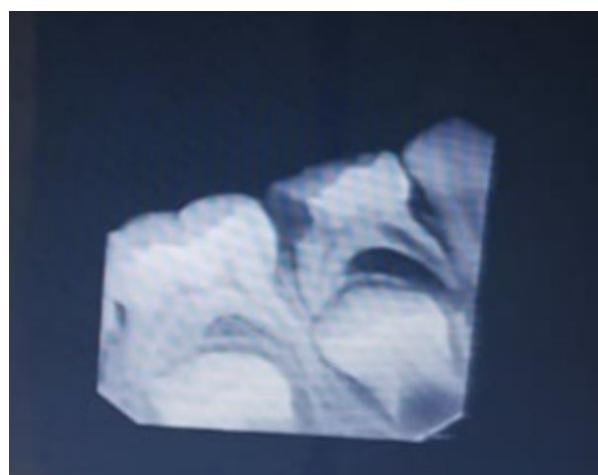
IOPA (intra oral periapical radiograph) showing presence of caries.
